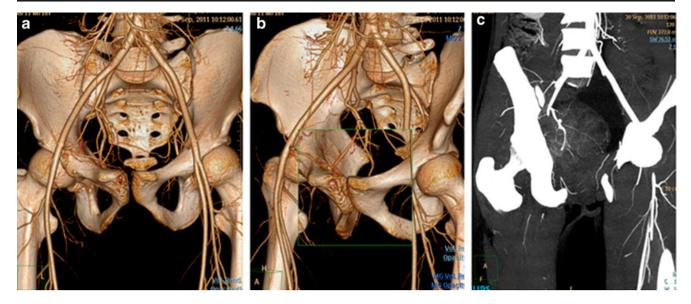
CT angiographic images (volume rendered, a & b and MIP, c) showing vascular anatomy in case of pelvic STS. Bony involvement can also be accurately demonstrated
